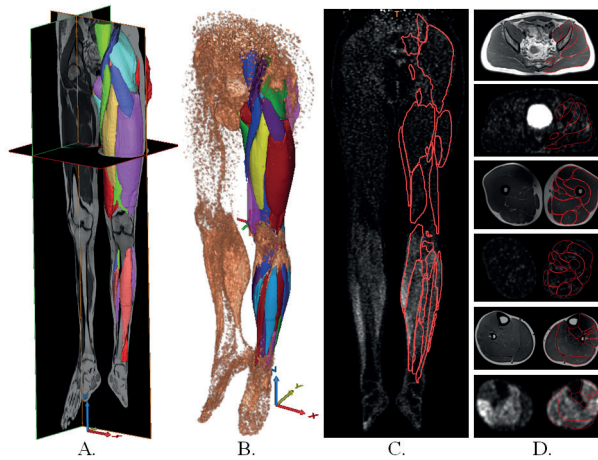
FDG-PET volumetric analysis: A. MRI scan with segmented muscle volumes. B. Segmented muscle volumes registered onto the PET scan. C. Frontal view of a PET scan with registered muscle volumes. D. MRI and PET scan slices of the hip, femur and tibia regions, with the registered muscle volumes.
